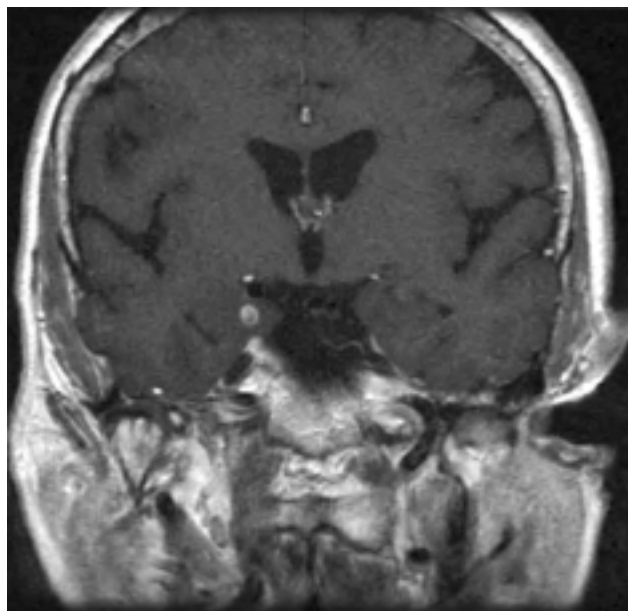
Magnetic resonance image of the brain shows a small focus of enhancement in the right uncus with a small amount of surrounding edema.
